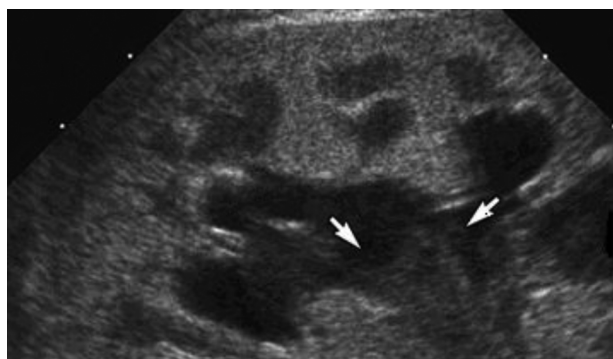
Ultrasound Showed Dilation of Calyces Without Obvious Dilation of Renal Pelvises
